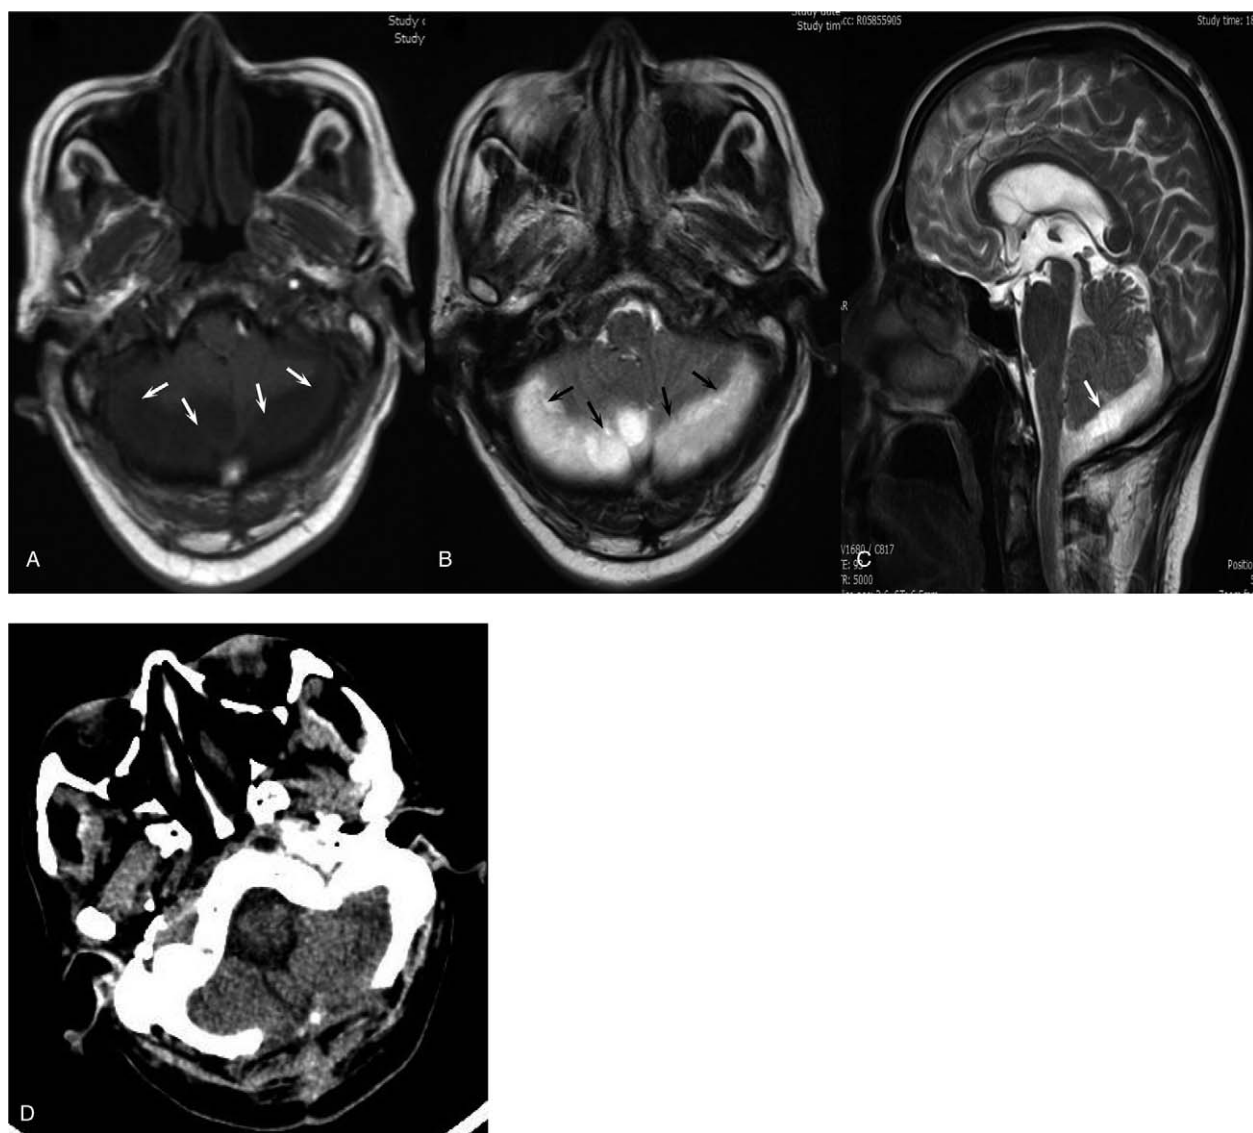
Imaging examination of the brain. (A, B and C) The initial contrast-enhanced MRI brain images. (A) T1 image. (B) T2 image. (C) T2 images of the sagittal position. The bilateral posterior fossa subdural effusion, subsequent hydrocephalus, and edema in the ventricle are displayed and marked with white arrows. (D) The follow-up CT of the brain after excision of the brain abscess.
